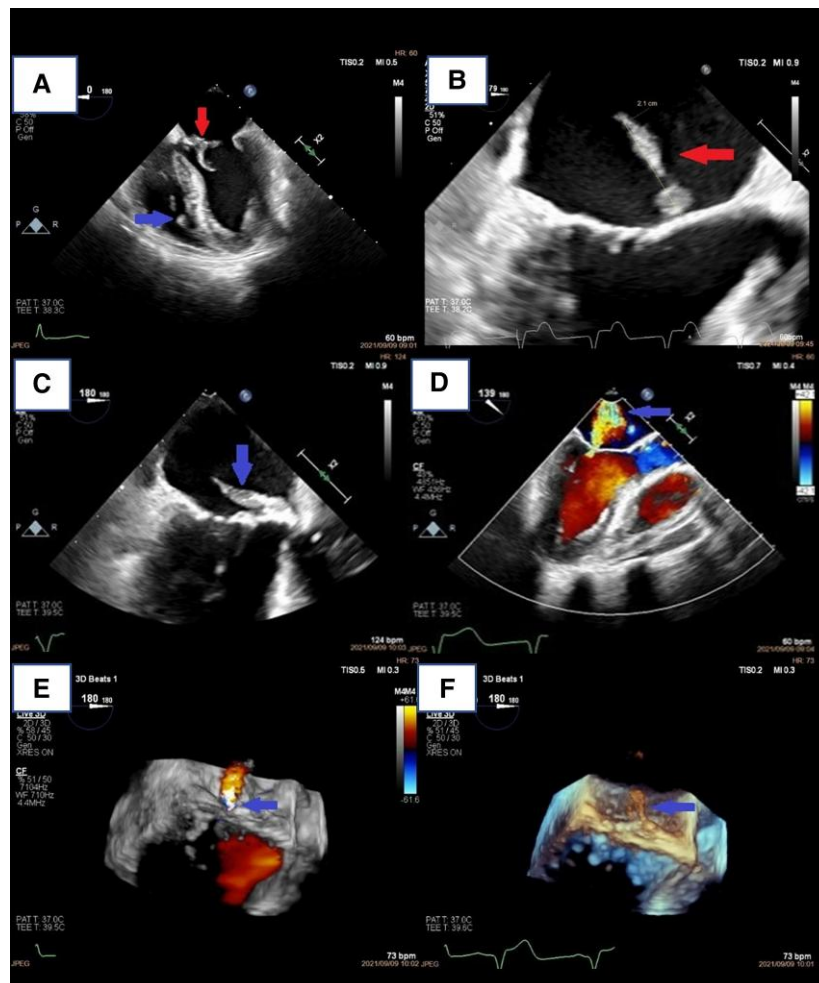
(A and B) Four-chamber view showing intact right ventricular lead (bottom horizontal arrow) and vegetation on the anterior MV leaflet (top arrow). (C and D) Large vegetation on the anterior mitral leaflet (C) complicated by mitral regurgitation (D). (E and F) Three-dimensional colour Doppler demonstrating mitral regurgitation (E) and large vegetation (F).
